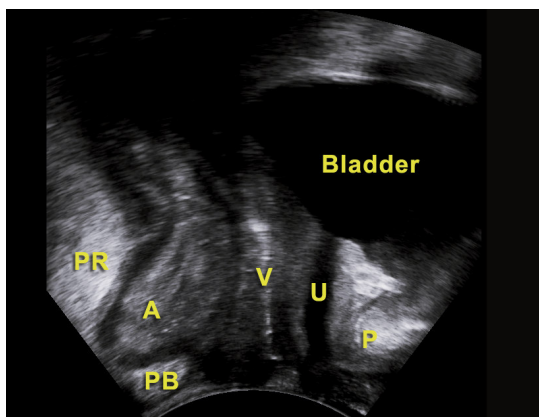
Normal ultrasound view during a sagittal perineal scan.
